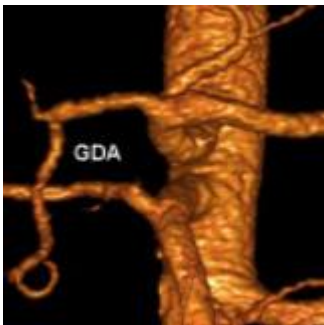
Computed tomographic angiogram of the celiac artery bifurcation. The gastrodudenal artery (GDA) can be seen arising from the common hepatic artery and descending caudally.
